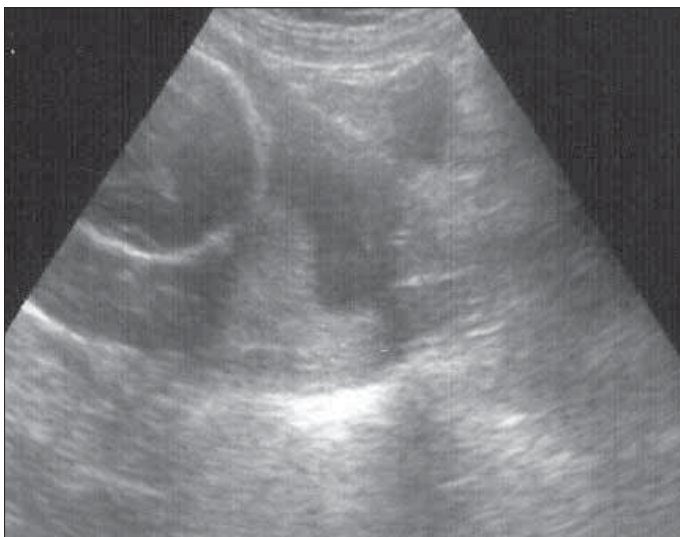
Ultrasound appearance of cervical dilatation and funnelling in case 2
